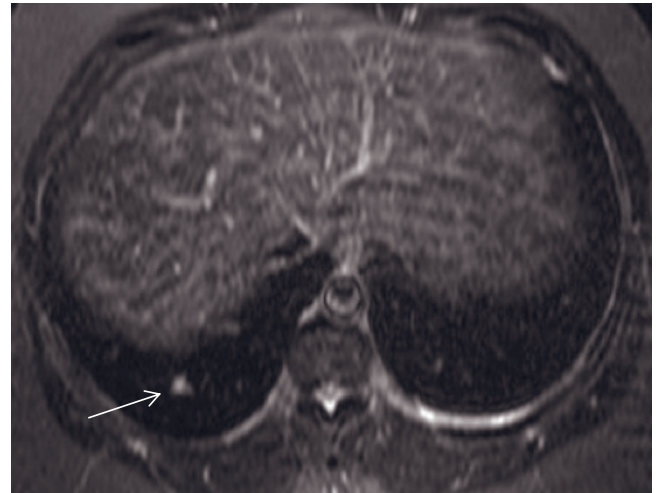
(Continued) coronal (*m, n*) and transverse (*o*) and transverse T1-weighted fat-suppressed postgadolinium 3D-GE (*p*) images demonstrate the left lung (thick arrows, *m, o, p*) and subclavian lymph node (arrow, *n*) metastases in patient 7 with endometrial cancer. The lung metastasis show intense peripheral enhancement (thick arrow, *p*) on postgadolinium image (*p*). Note that there is an infiltrate (thin arrows, *o, p*) in the left lung. Transverse T1-weighted postgadolinium fat-suppressed 3D-GE images (*q, r*) at 3.0T demonstrate right pleural metastases and pleural metastatic thickening and a very small left lung metastasis (arrow, *r*) in patient 8 with HCC.
